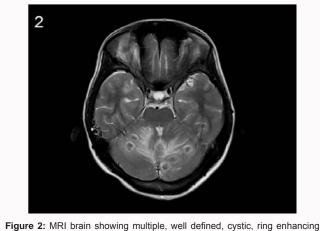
MRI brain showing multiple, well defined, cystic, ring enhancing lesions of varying sizes with surrounding vasogenic edema suggestive of tuberculomas.
